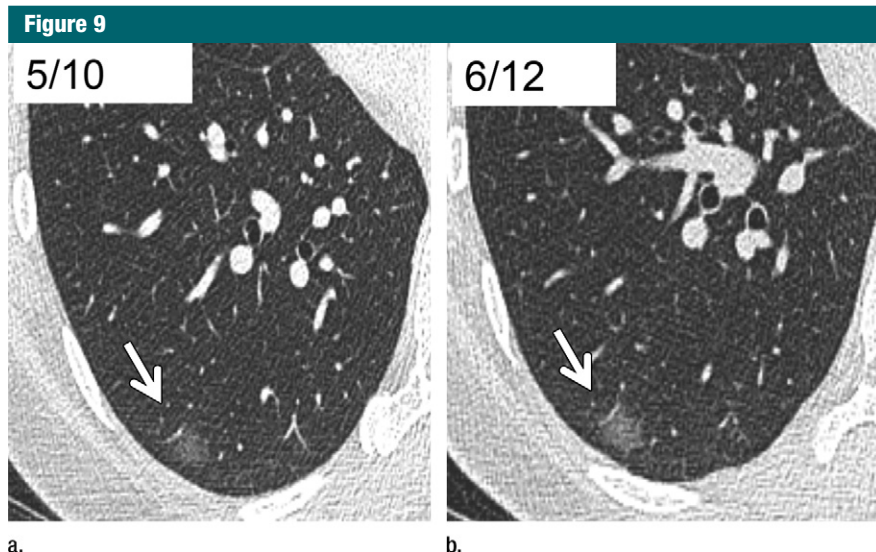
Transverse 1-mm CT sections through the right lower lobe. (a) A well-defined 6-mm ground-glass nodule (arrow) can be seen. (b) Image obtained more than 2 years after a shows a subtle increase in the size of the nodule (arrow). This finding was confirmed by noting the slightly altered relationship to adjacent vascular structures. Such subtle progression can be detected only by using 1-mm contiguous sections. Findings are consistent with adenocarcinoma in situ or minimally invasive adenocarcinoma, and continued yearly follow-up is recommended.
